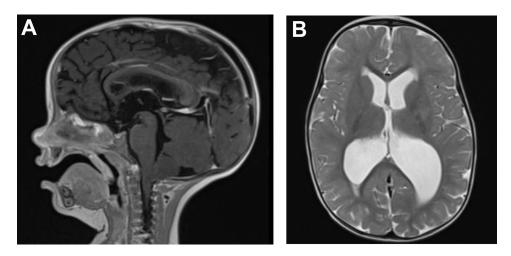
14-month-old with NF-1 presented with enlarged ventricles, transependymal CSF, and low tonsil position. Patient underwent Chiari decompression and subsequent treatment with ETV. T2-weighted MRI (A) sagittal and (B) axial views
